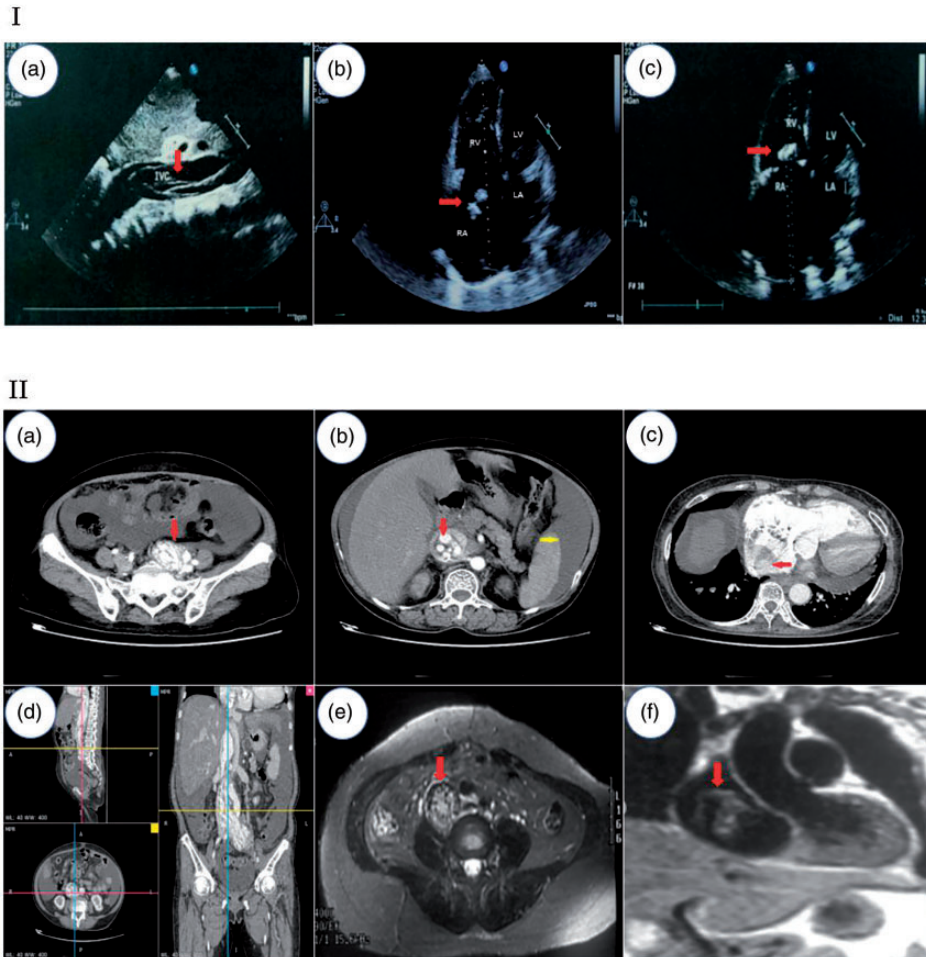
(I) Cardiac ultrasound shows a floating mass in the inferior vena cava and right heart. (II) The red arrows in the three images (a), (b), and (c) represent intravenous leiomyomatosis (IVL) in the internal iliac vein, inferior vena cava, and right atrium, respectively. The yellow arrow in (b) shows ascites. (d) Multiplanar reconstruction of inferior vena cava computed tomography. The IVL location is determined from the sagittal, cross-sectional, and coronal planes. Magnetic resonance imaging shows widening of the vena cava and an irregular soft tissue signal visible in the inferior vena cava and right atrium.
